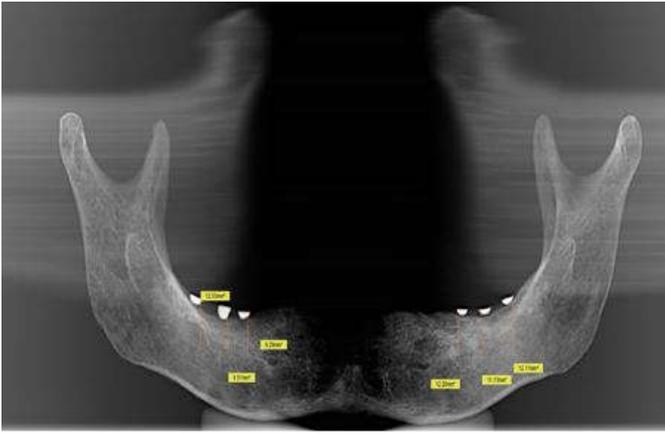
Radiographic length measurement using OPG software
